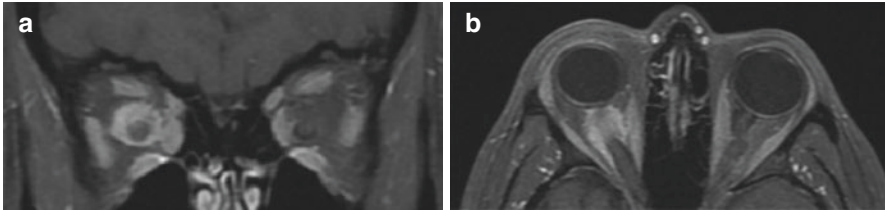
T1-weighted MRI orbits with fat saturation and gadolinium. (a) Coronal view with enhancement and thickening surrounding the optic nerve (doughnut sign). (b) Axial view with enhancement and thickening along both sides of the right intraorbital optic nerve (tram-track sign). (© AD Henderson 2021. All Rights Reserved)
